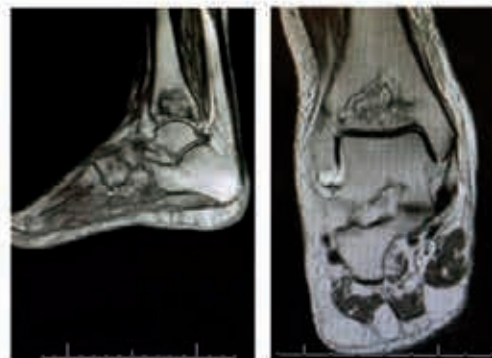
Figure Figure 2: Ankle MRI showing avascular necrosis of the distal tibia without obvious involvement of the talocrural joint.
